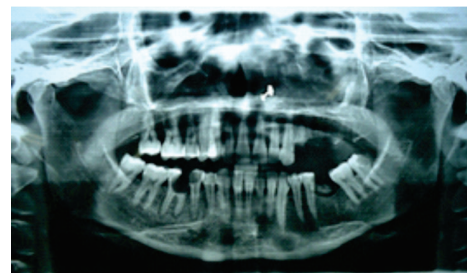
Orthopantomograph (OPG) of maxillary osteomyelitis
